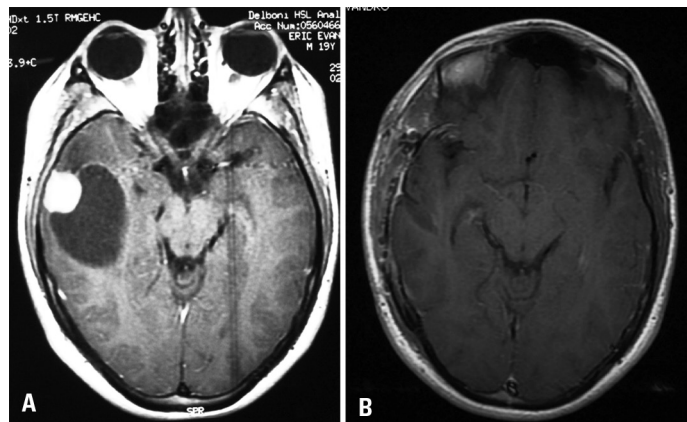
[A] MRI showing a right temporal solid-cystic lesion in Axial view. [B] Pos operative MRI in axial view.
